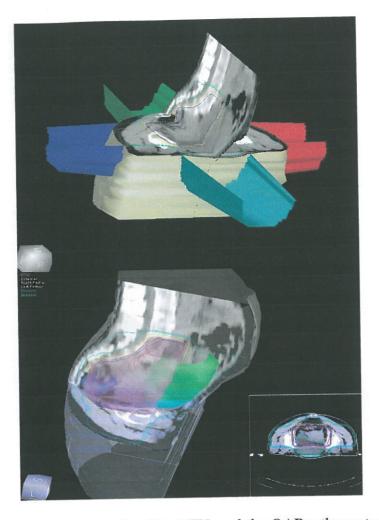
CT-based 3D treatment plan. The PTV, and the OARs; the rectum and the bladder are presented with the isodose coverage on a sagitally and axially opened and on a partially transparent 3D reconstruction. The PTV includes the gross tumor volume (GTV), uterus, parametria, the whole extend of the vagina, internal and common iliac lymph nodes.
